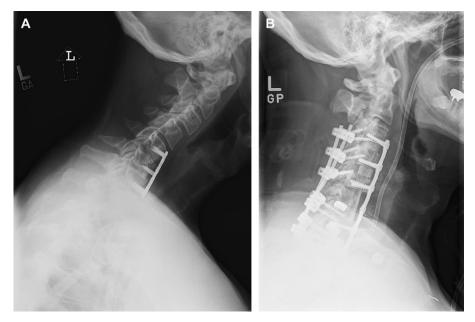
(A) Lateral radiograph of a 63-year-old man with a prior two-level correction to anterior cervical discectomy and fusion with progressive kyphotic deformity. (B) Lateral postoperative radiograph after a two-staged procedure, including C6 corpectomy, C3-T1 ACDF, and C3-T1 posterior spinal fusion, demonstrates near correction of prior deformity.
